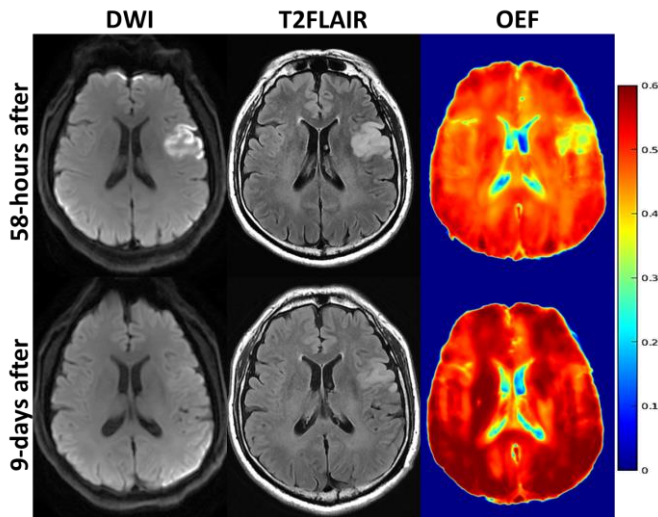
The DWI and T2FLAIR structural images and the estimated OEF maps of a stroke patient 58 hours and 9 days after stroke onset.
